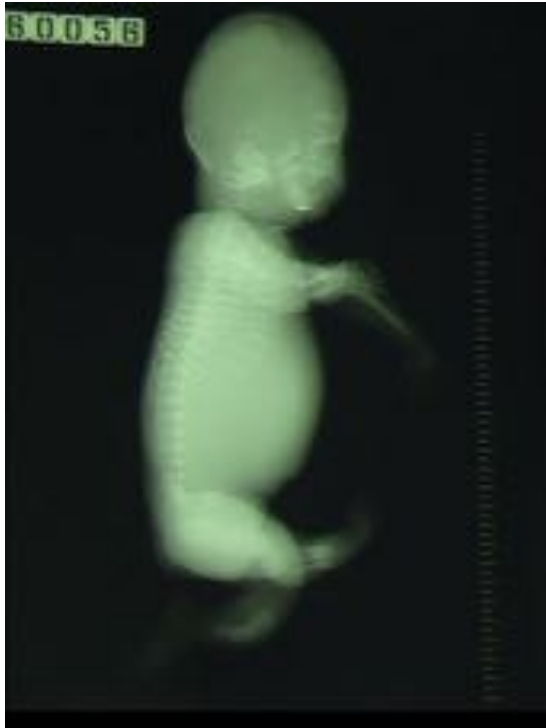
Lateral radiograph of the whole skeleton of the fetus at 30 weeks of age, showing a few mildly enlarged lumbar vertebral bodies and the irregularly shaped ribs. There is decreased skull ossification and a dense mandible.
